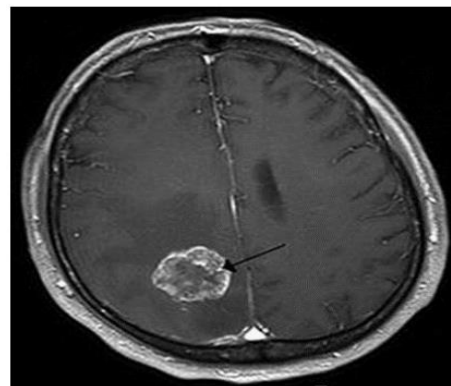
Brain metastasis in the right cerebral hemisphere from lung cancer. Magnetic Resonance Imaging.
